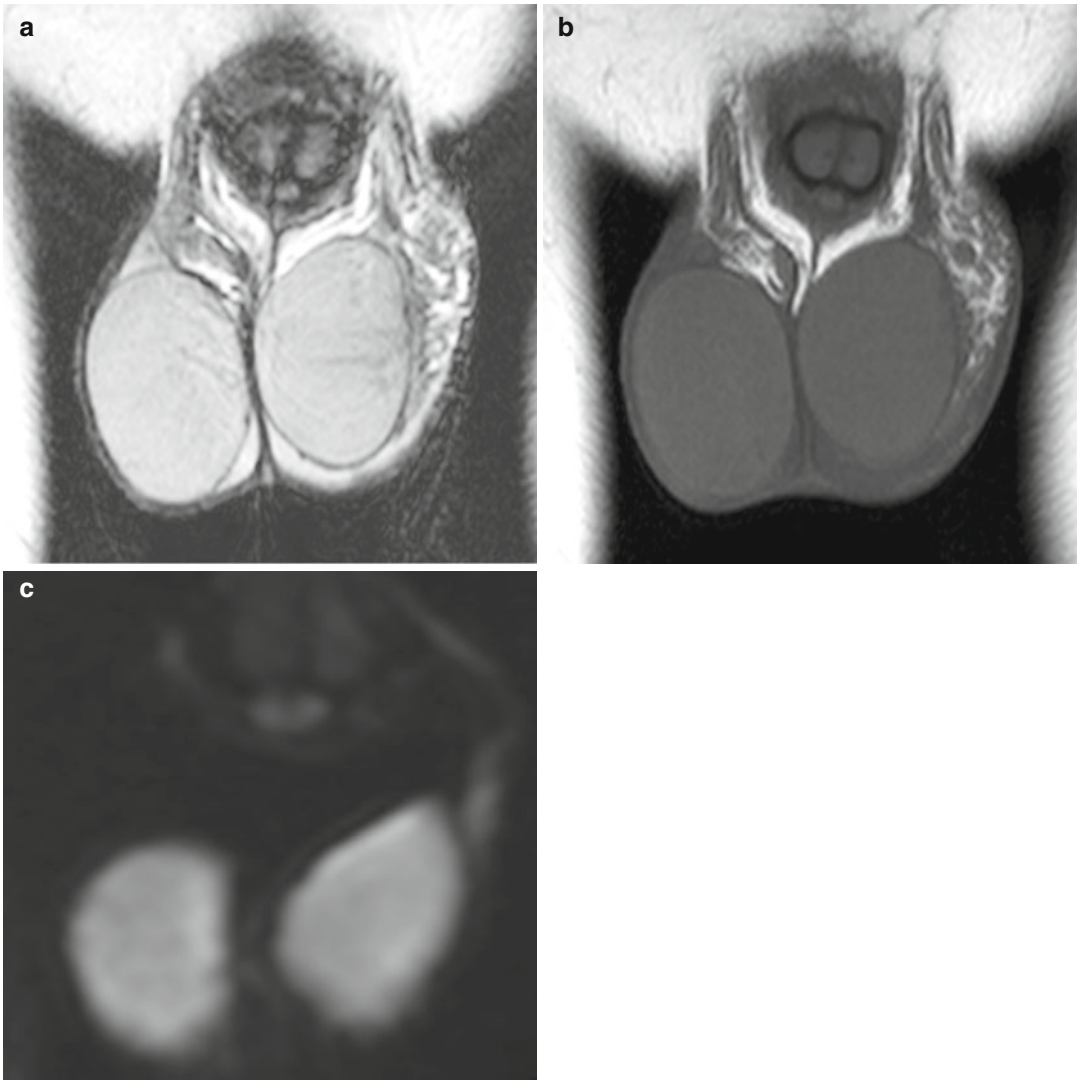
Appearance of the normal testes on MR imaging. Coronal images. (a, b) The testes show high signal intensity on T2- and intermediate signal intensity on T1-weighted images, respectively. The tunica albuginea
